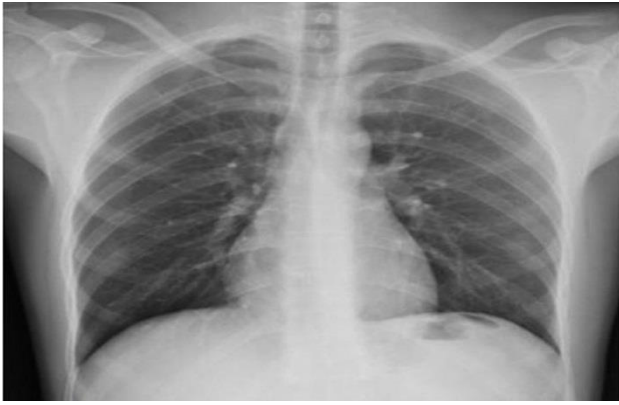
Chest X-ray did immediately after admission without any evidence of pneumomediastinum or pneumoperitoneum.
